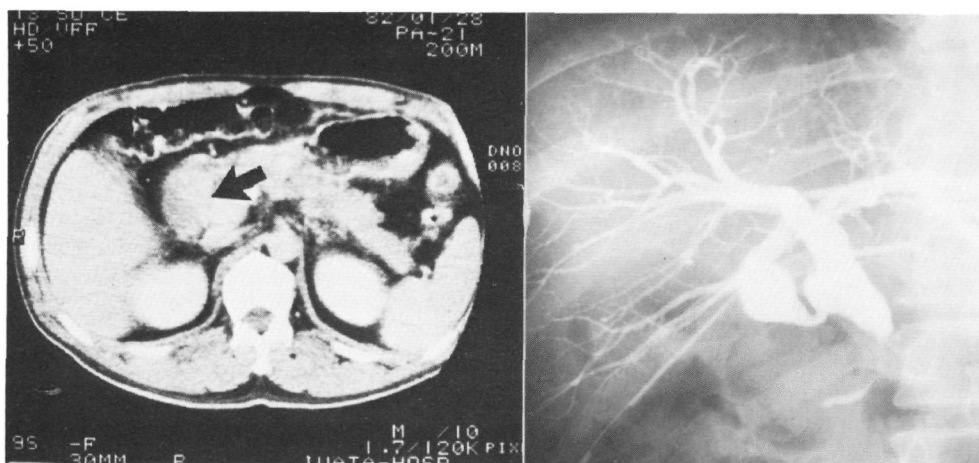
Computed tomograph (left) demonstrates the presence of a mass in the distal common bile duct (arrow). Percutaneous transhepatic cholangiograph (right) shows an annular stricture of the common bile duct distal to the cystic duct. The gallbladder is seen to be shrunken and deformed in irregular shape.
